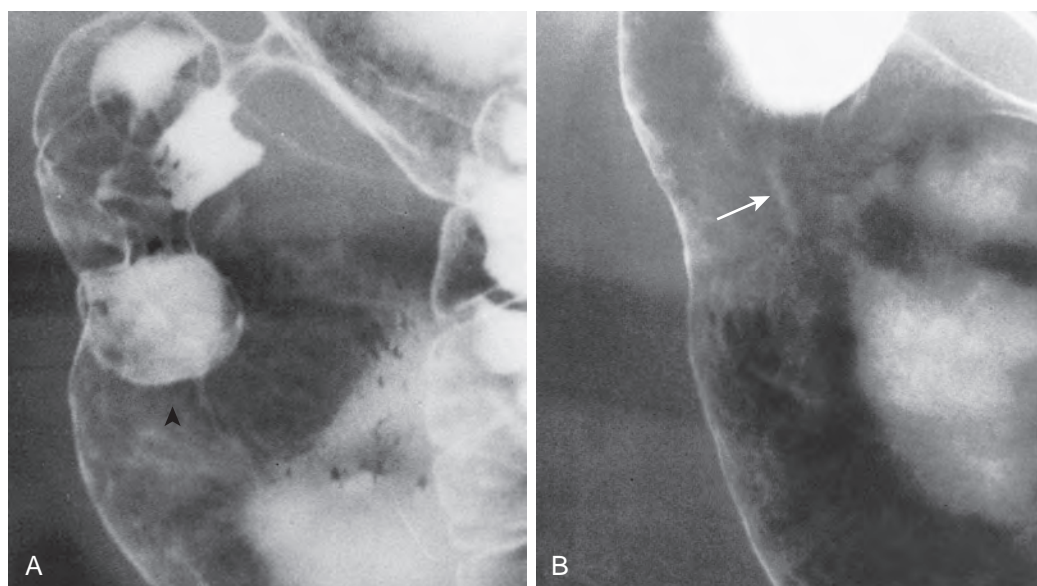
Development of a linear ulcer during healing. A. A large, round ulcer (arrowhead) is seen on the posterior wall of the antrum. B. Follow-up study 8 weeks later shows substantial ulcer healing with a residual linear ulcer (arrow) in this location. (From Levine MS, Creteur V, Kressel HY, et al: *Benign gastric ulcers: Diagnosis and follow-up with double-contrast radiography*. Radiology 164:9–13, 1987.)
